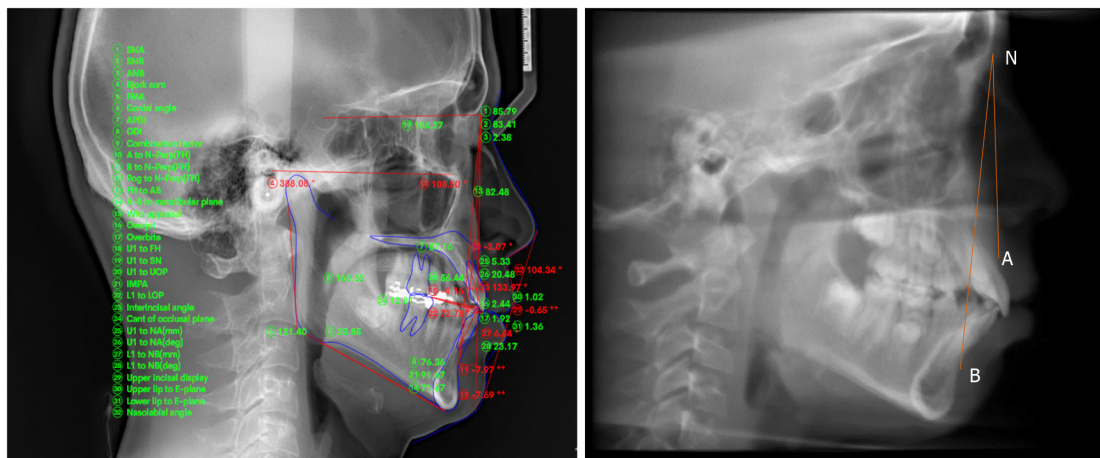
Cone beam computed tomography derived cephalogram and analysis.
